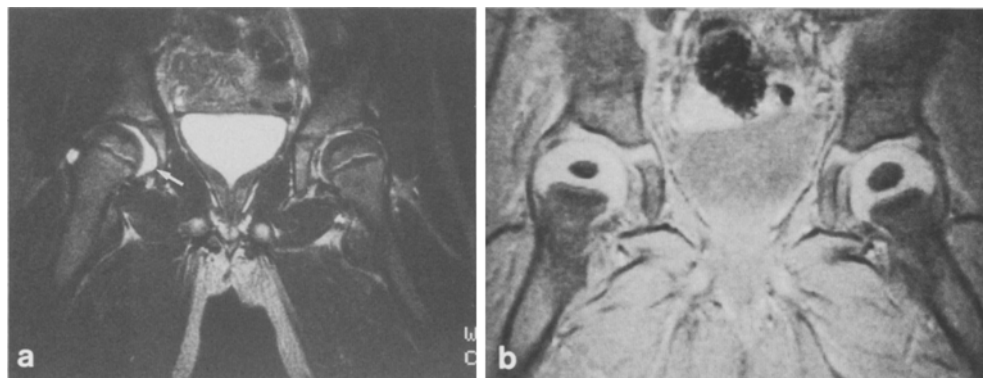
a Four and half years old child with successful treated congenital dislocation on both sides. In T2-weighted Spin-Echo image (200/90) clearly evidence of effusion (→) on the right hip. b One year old child with mild congenital dislocation on both sides. Under use of Gradient-Echo-Sequence FLASH 0.07/10 with an Flip angle of 30 with good differentiation of all important structures of the hip
